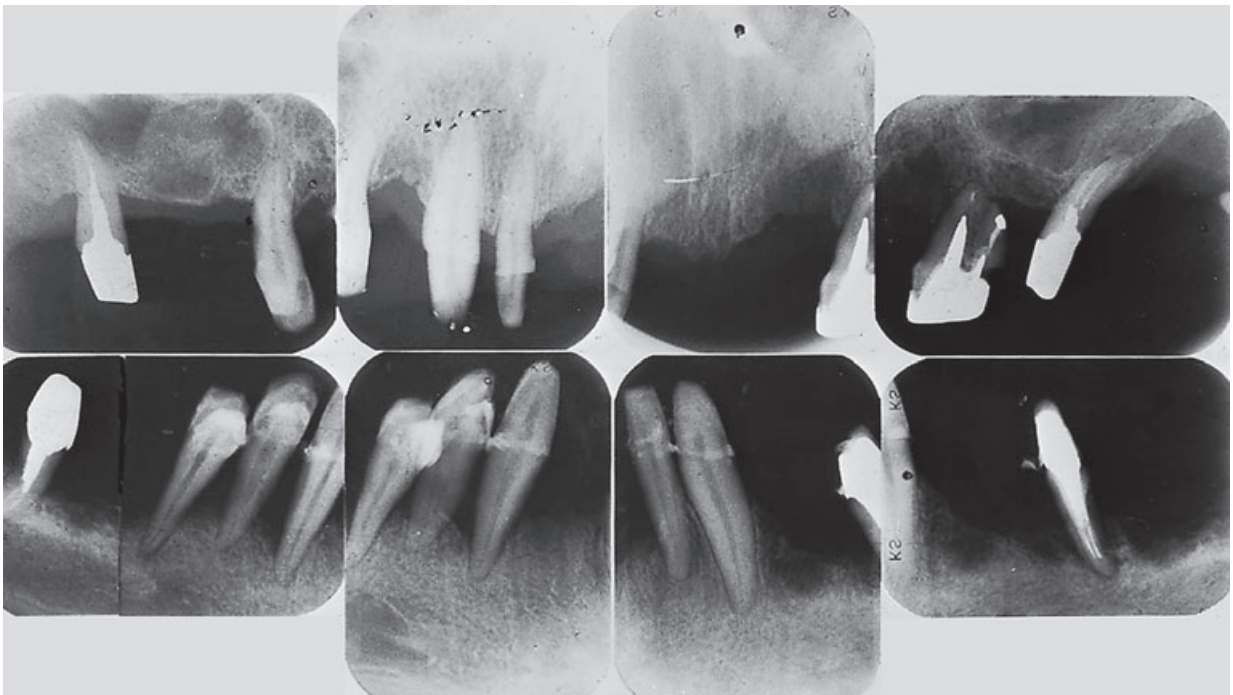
Case B. Radiographs obtained after periodontal treatment and preparation of the abutment teeth for two fixed splints.
